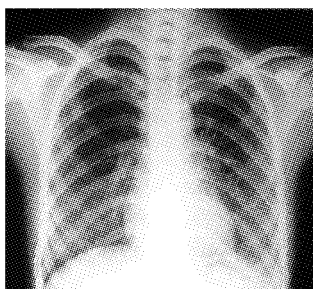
Frontal chest radiograph of a 3-year-old girl with SARS. A: Radiograph on the 1st day shows patchy opacity in the right upper lung lobe involving the right lung hilum. B: Seven days later, obvious progression of the focus of the lesion. C: Fourteen days later, the opacity disappeared.
